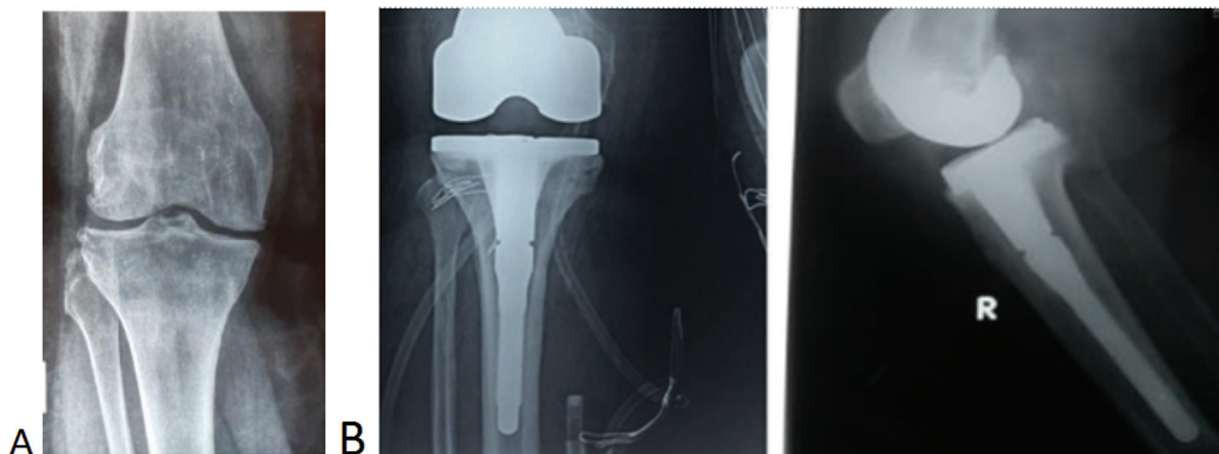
Preoperative (A) and postoperative (B) X-ray of 59-year-old female (BMI = 32 kg/m²) with the stemmed tibial component. BMI, body mass index.
